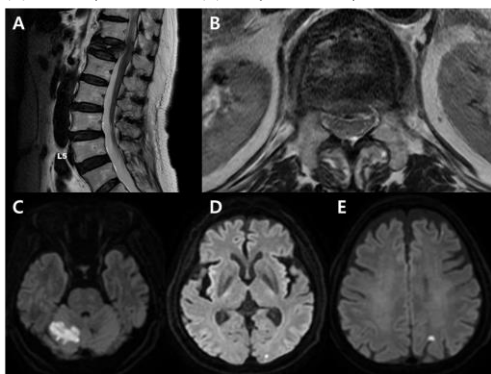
T2-weighted sagittal (A) and axial (B) MRI reveal acute compression fractures in L1 with resultant severe central canal stenosis. High signal intensity was observed in right superior cerebellum (C) and left occipital (D) and parietal (E) in DWI.
